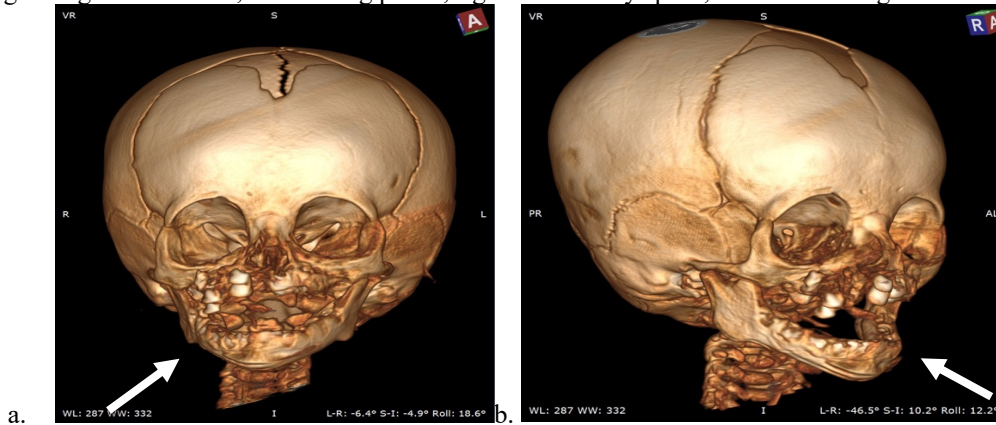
CT scan 3D reconstruction frontal (a) and lateral oblique (b) view. Bone destruction observed at right maxilla region with tooth bud displacement (white arrow).
